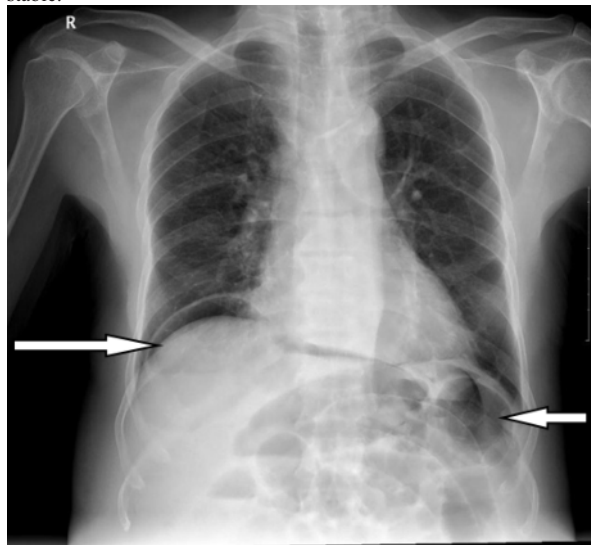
Xray abdomen showing b/l gas under diaphragm
